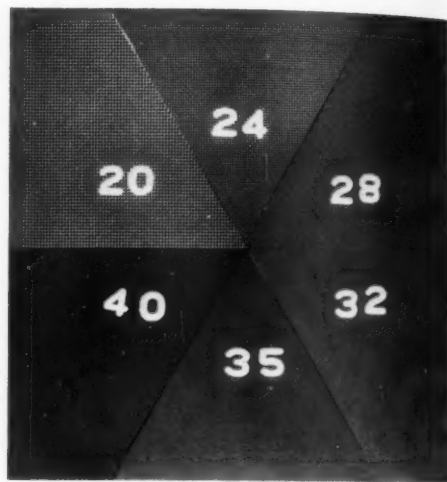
Wire screen cloth test object. This direct radiograph shows the patterns of varying texture used for resolution tests on the cine-systems. The numerals indicate the number of line pairs per inch for each sector.
